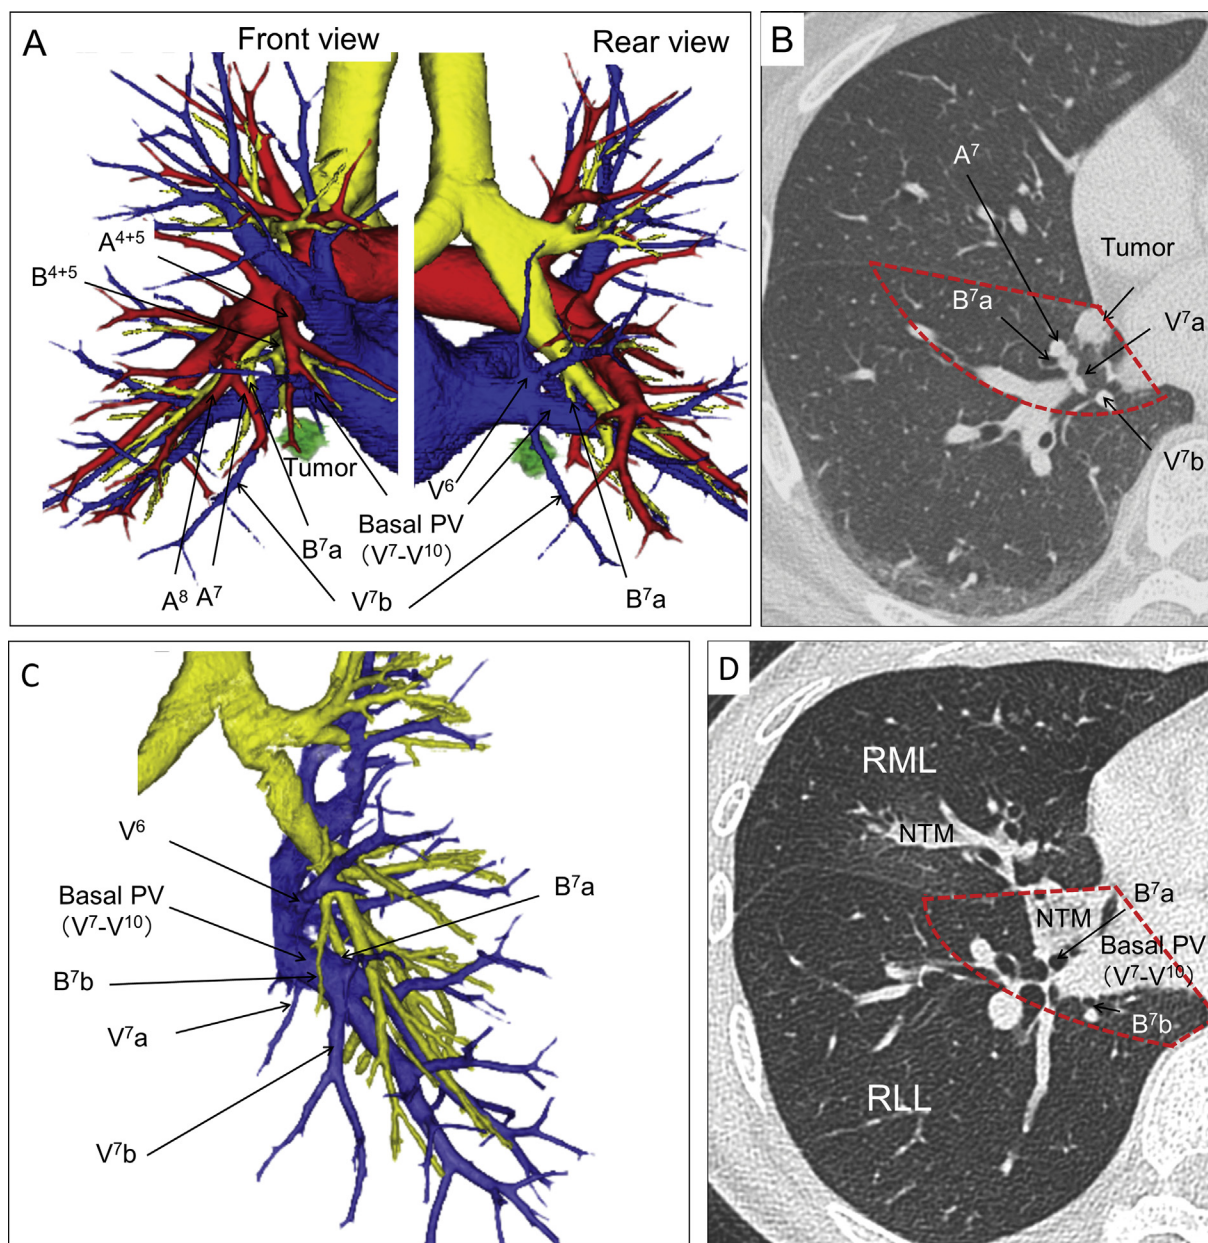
(A, C) Three-dimensional computed tomography angiography and bronchography and (B, D) multidetector-row computed tomography images of case 1 (A, B) and case 3 (C, D). The red dotted line surrounds the S<sup>7</sup> segment. (A = artery; B = bronchus; NTM = nontuberculous mycobacteria; PV = pulmonary vein; RLL = right lower lobe; RML = right middle lobe; V = vein.)
